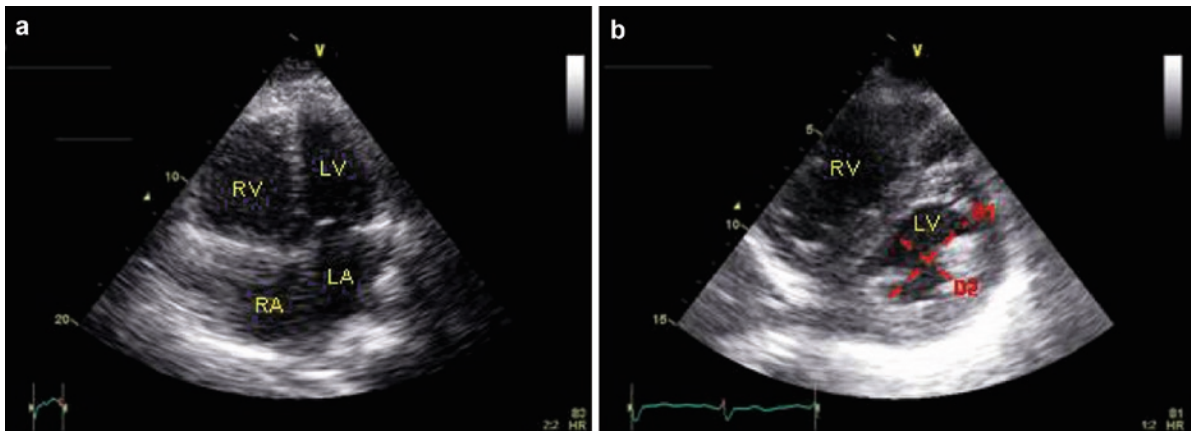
Acute cor pulmonale in a patient admitted for acute pulmonary embolism. (a) Apical four-chamber view showing severe right ventricular dilatation (right/left ventricle diameter
